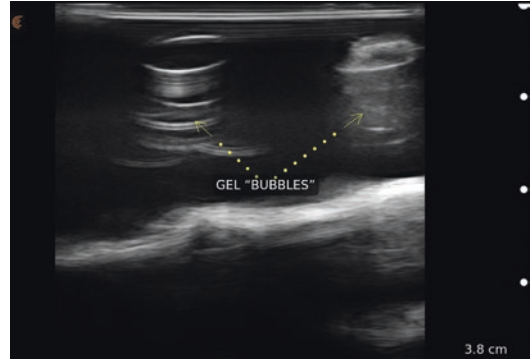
Grayscale ultrasound image of an ex vivo silicone gel breast implant exhibiting echogenic swirling lines indicative of gel bubbles
